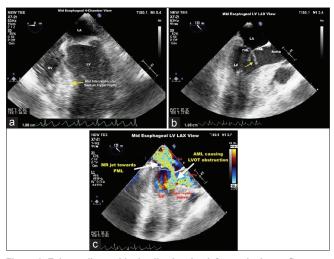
Echocardiographic details showing left ventricular outflow tract obstruction. (a) Mid-septum hypertrophy (Catenoid septum). (b) Residual anterior mitral leaflet beyond the point of coaptation shown by yellow arrow dragged into left ventricular outflow tract causing obstruction. (c) Color Doppler shows flow turbulence in left ventricular outflow tract and eccentric mitral regurgitation
